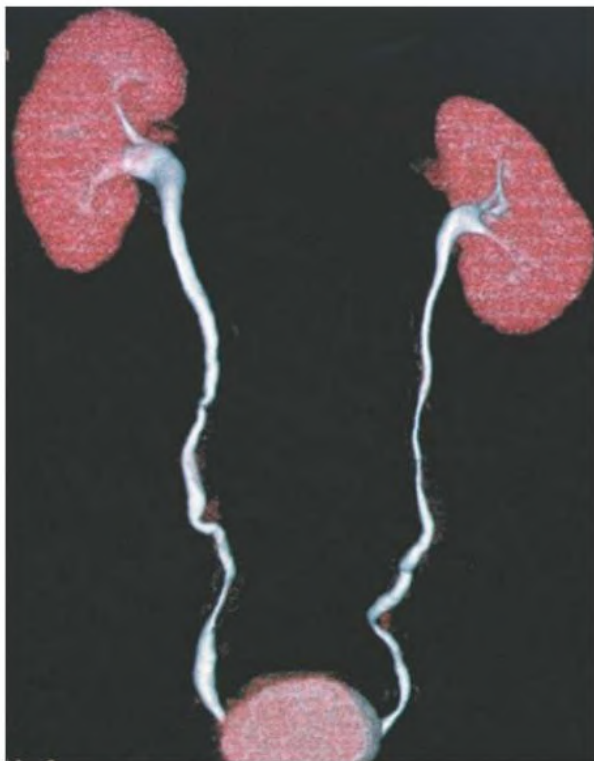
Noncontrast Computed Tomography (CT) of Bladder and Kidney. Computer-reformatted, volume-rendered CT urogram obtained from axial CT acquisition.
